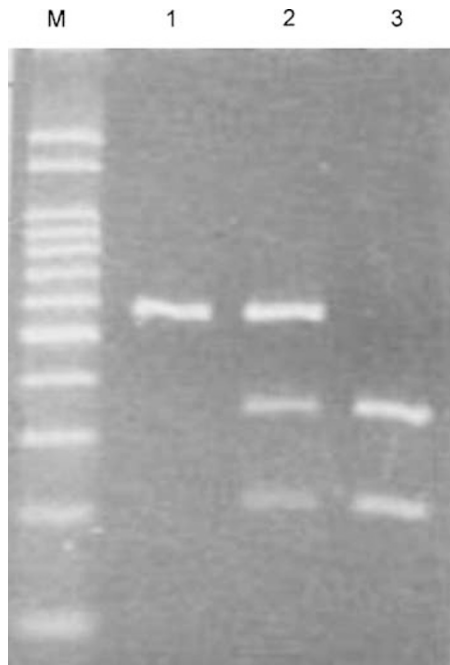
PCR-based restriction analysis of *PAX6* polymorphism at position –12 of intron 9 (IVS9-12C to T) using *BccI* restriction enzyme. Digested samples were analysed by electrophoresis on a 3% agarose gel. PCR of the polymorphic region resulted in an undigested fragment of genotype CC (681 bp; lane 1), a heterozygote with genotype CT (lane 2), and a digested fragment representing genotype TT (491 bp fragment and 190 bp fragment; lane 3). Lane M: 100 bp DNA ladder.
